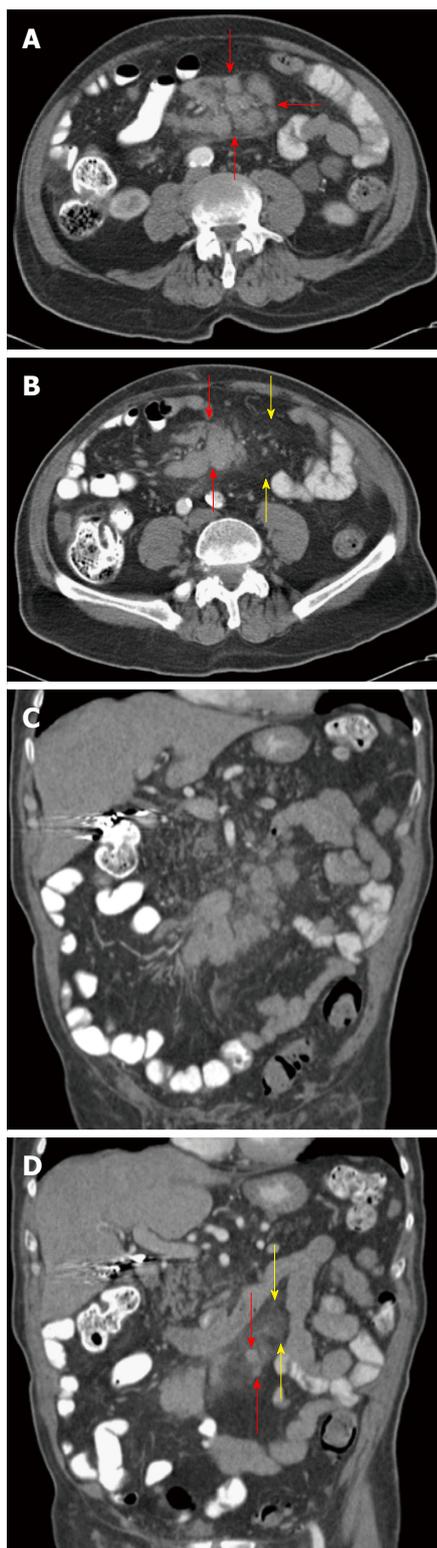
Mesenteric panniculitis in a patient with non-Hodgkin lymphoma. A: Axial computed tomography (CT) scan at the level of the inferior aspect of the kidneys shows extensive mesenteric adenopathy (red arrows); B: Axial CT image obtained more caudally, at the level of the iliac crest reveals mesenteric adenopathy (red arrows) and synchronous mesenteric panniculitis (yellow arrows) characterized by hazy mesenteric fat and separation of the mesenteric vessels; C: Coronal reformatted CT image demonstrates the extensive mesenteric adenopathy (red arrows); D: Coronal reformatted CT image, take dorsal to (C) depicts synchronous mesenteric adenopathy (red arrows) and mesenteric panniculitis (yellow arrows).
